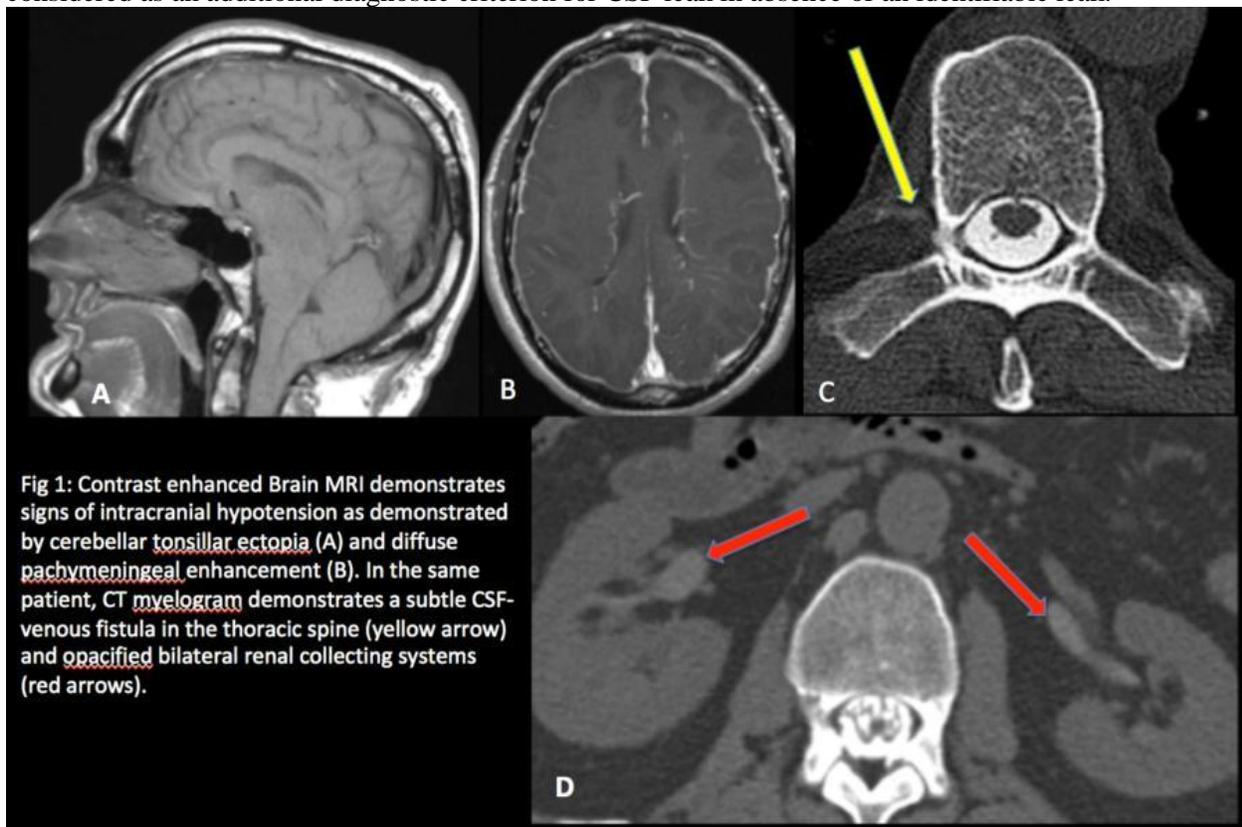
Contrast enhanced Brain MRI demonstrates signs of intracranial hypotension as demonstrated by cerebellar tonsillar ectopia (A) and diffuse pachymeningeal enhancement (B). In the same patient, CT myelogram demonstrates a subtle CSF-venous fistula in the thoracic spine (yellow arrow) and opacified bilateral renal collecting systems (red arrows).
